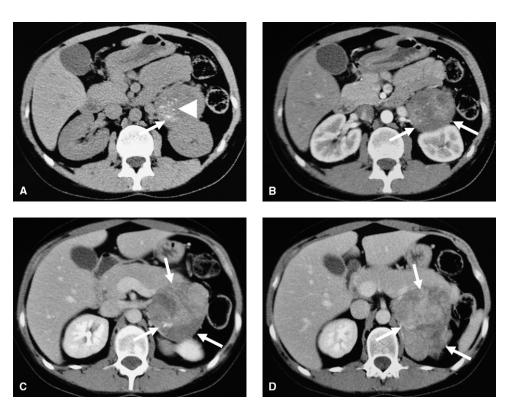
Left adrenal carcinoma. Unenhanced (A) and enhanced CT study in arterial (B) and venous (C, D) phases. A large mass with irregular shape and borders (white arrows) is shown (A–D). Some calcifications (white arrowhead) are detectable on unenhanced examination (A). After administration of iodinated CA, the mass demonstrates uneven enhancement due to heterogeneous content and pathological vascularization (B–D).
